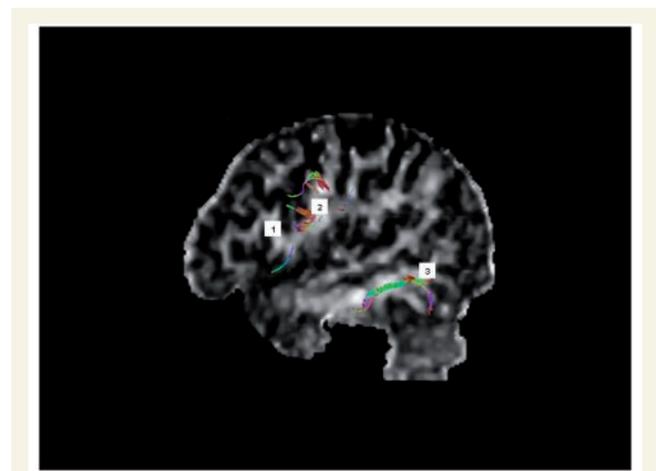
Localizing the endpoints of the AF. Diffusion Tensor Imaging-fibre tractography of the superior longitudinal fasciculus with fibres directional-colour-coded depicted on a left parasagittal brain fractional-anisotropy MR image. The frontal lobe appears on the left side. The following gyrus white matter banks are numbered for easy landmark identifications: 1 = inferior frontal gyrus, pars opercularis (Broca’s area); 2 = Precentral gyrus; 3 = middle temporal gyrus. Notice the fibres emerging in the middle temporal gyrus and in the precentral gyrus. No emerging fibres are seen in the Broca’s area (Images courtesy of Miami Children’s Hospital, Department of Radiology).
